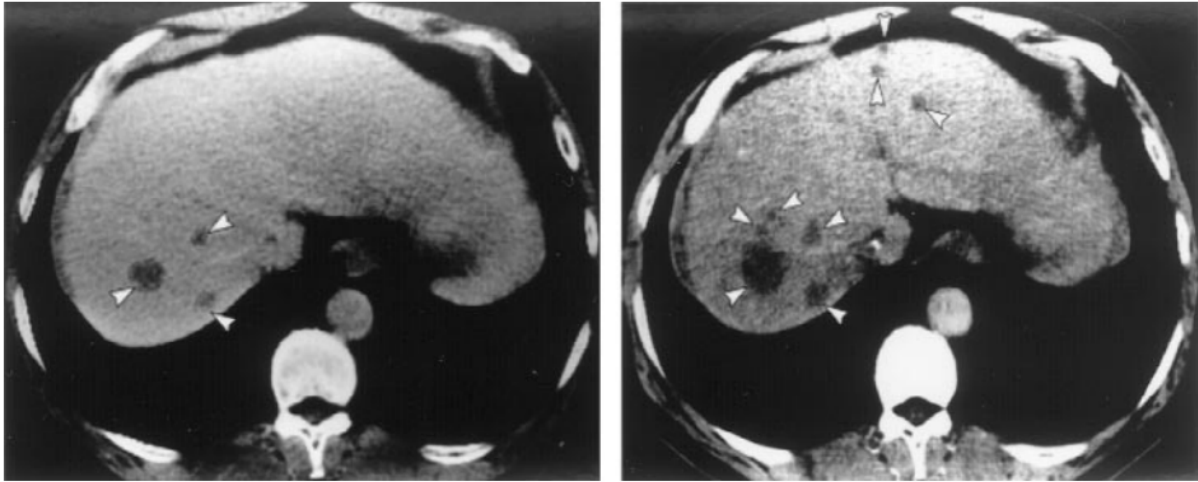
Examples of liver CTs with multiple metastatic tumours. The CTs on the left and right were taken 432 and 559 days after the primary tumour diagnosis, respectively. By taking multiple CT images in the form of slices throughout the whole liver, the number and size of all detectable liver metastases (indicated by white arrows) can be measured. Reproduced from Iwata et al. (2000) with permission from Elsevier.*
